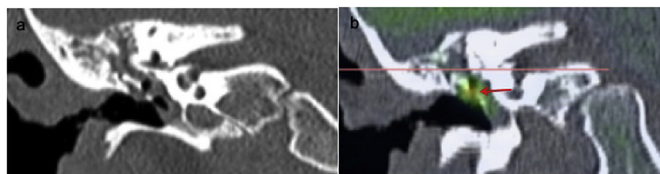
Coronal images show cholesteatoma (red arrow) medial to the ossicles with high confidence (score 5) on the fused image (b) but this is not confidently depicted (score 3) on CT (a). (For interpretation of the references to colour in this figure legend, the reader is referred to the Web version of this article.)
